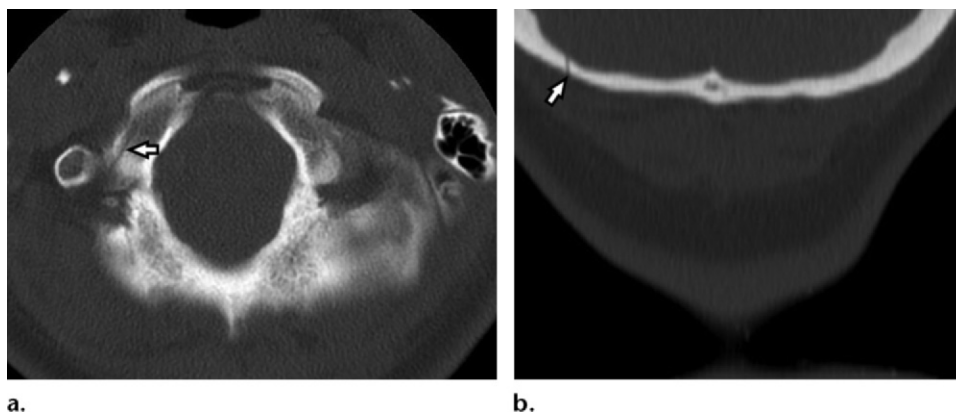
Anderson and Montesano type II occipital condyle fracture. (a) Axial CT image demonstrates a linear fracture (arrow) in the right occipital condyle. (b) Coronal CT reformation image demonstrates that the fracture (arrow) extends from the lateral aspect of the occipital bone.
